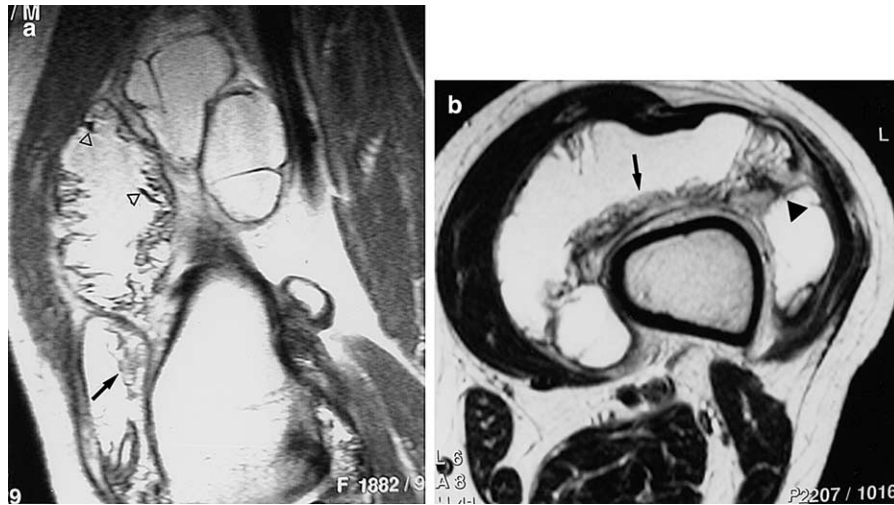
Pigmented villonodular synovitis of the knee: MR imaging. (a) Sagittal Proton density Fast Spin Echo (TR/TE:4000/22 ms) and (b) T2-weighted Fast Spin Echo (TR/TE:4000/70 ms) demonstrate the intraarticular effusion and the synovial fatty elements (arrows). The low-signal intensity frond-like projections (open arrowheads) were erroneously attributed to chemical shift artifact. The low-signal intensity lesion (arrowhead) in (b) was not originally evaluated.
